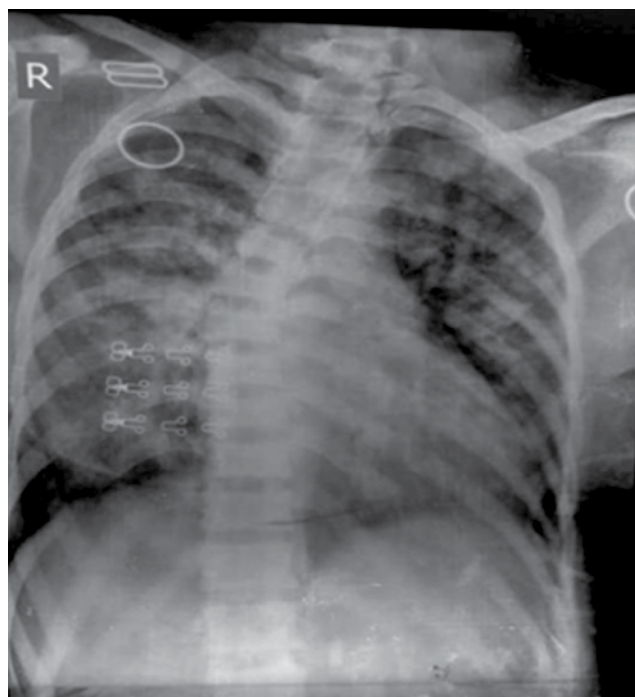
Chest X-ray showing bilateral pulmonary infiltrate with scoliosis.
